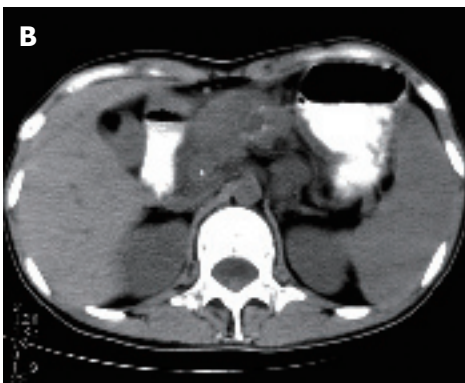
Enhanced CT showing notable circular thickening of intestinal wall with homogeneous density.
